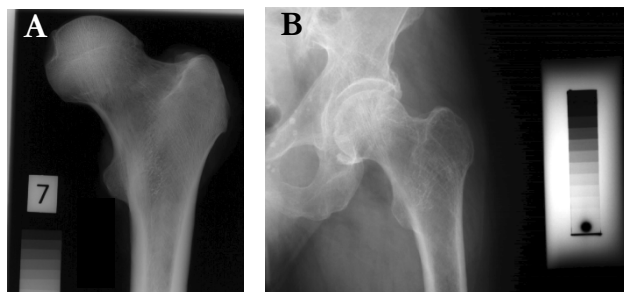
A radiograph of the proximal femur, with an aluminum step-wedge.
